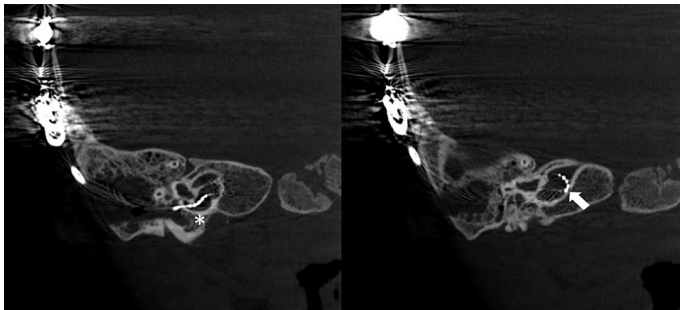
Coronal view CT: cochlear implant electrodes reach the internal acoustic canal (white arrow) from the base of the cochlea (asterix).
